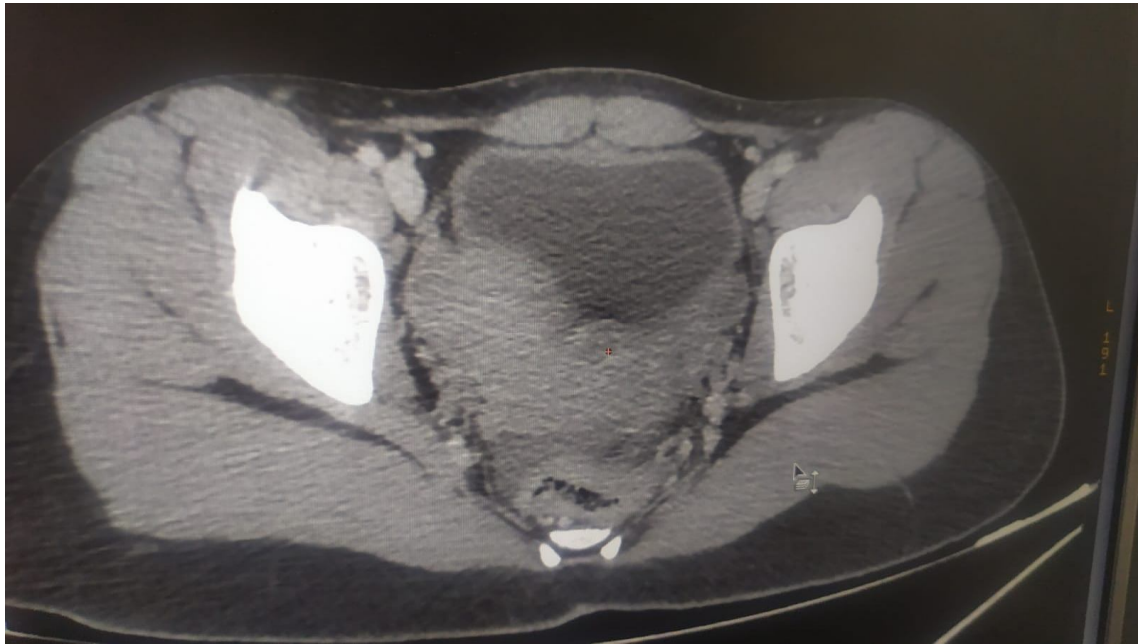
abdominal CT image showing adenolymphitis
